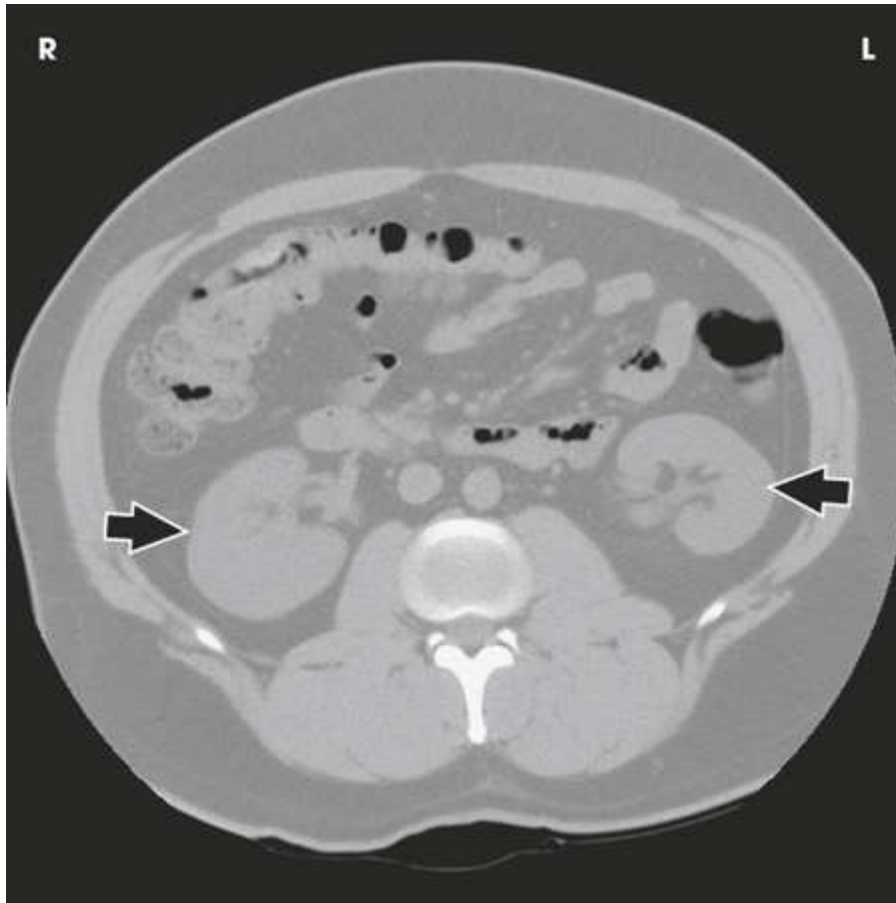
CT of abdomen without contrast media showing parenchyma and renal pelvis of both kidneys (*arrows*). Courtesy Karl Mockler, RT[R].
